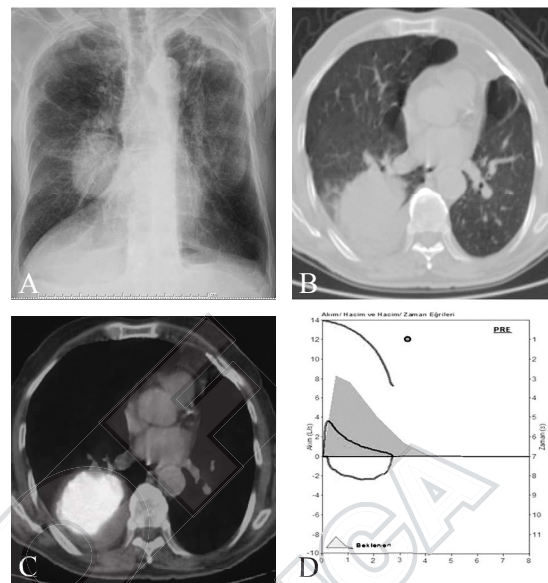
A-D) A 73-year-old male patient was diagnosed with concurrent COPD and lung cancer. Chest radiography, ¹⁸F-DG-PET/CT scan and spirometric flow-volume curves show the pulmonary mass and airway obstruction.
